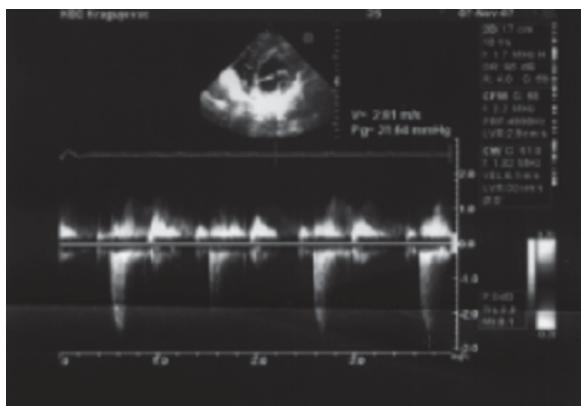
Transthoracic echocardiogram of the presented patient
